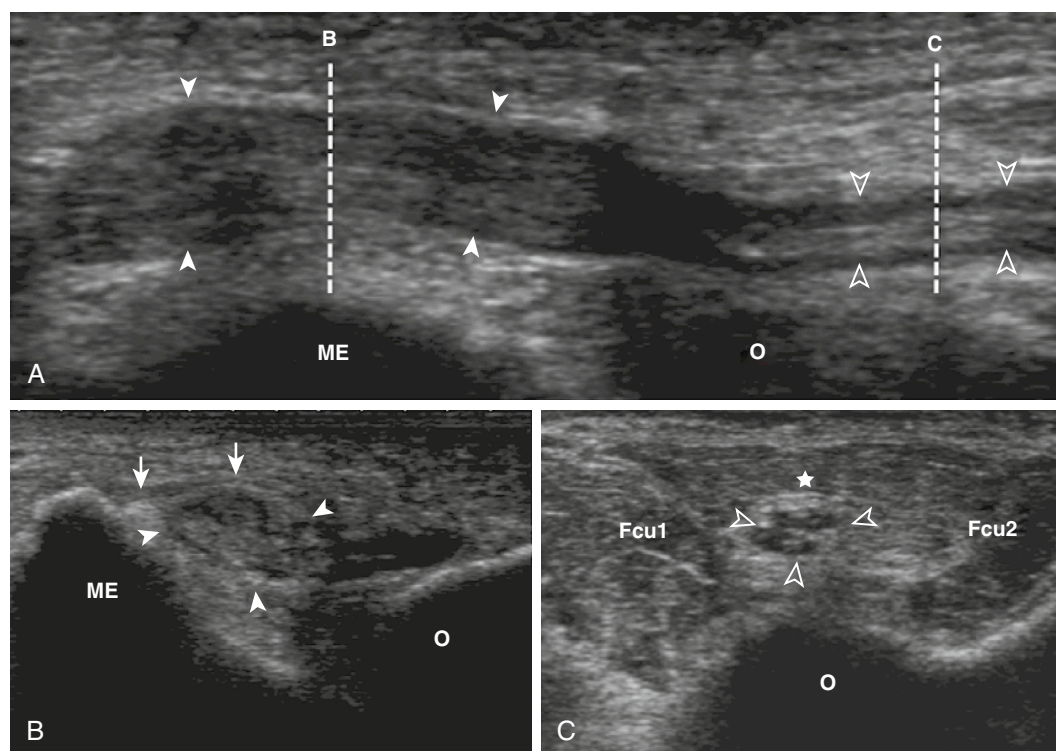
CUBITAL TUNNEL SYNDROME. A, Long-axis, 5- to 14-MHz ultrasound image was obtained over the posteromedial elbow shows an enlarged ulnar nerve (*closed arrowheads*) at the level of the condylar groove between the medial epicondyle (ME) and the olecranon (O). The ulnar nerve regained its normal size and fascicular aspect (*open arrowheads*) at the cubital tunnel level, passing between the two heads of the flexor carpi ulnaris (Fcu1, Fcu2) and under the arcuate ligament (*star*). Notice the slightly hypertrophic Osborne ligament (*arrows*). B and C, Short-axis ultrasound images correspond to the *dotted lines B and C* in part A.
